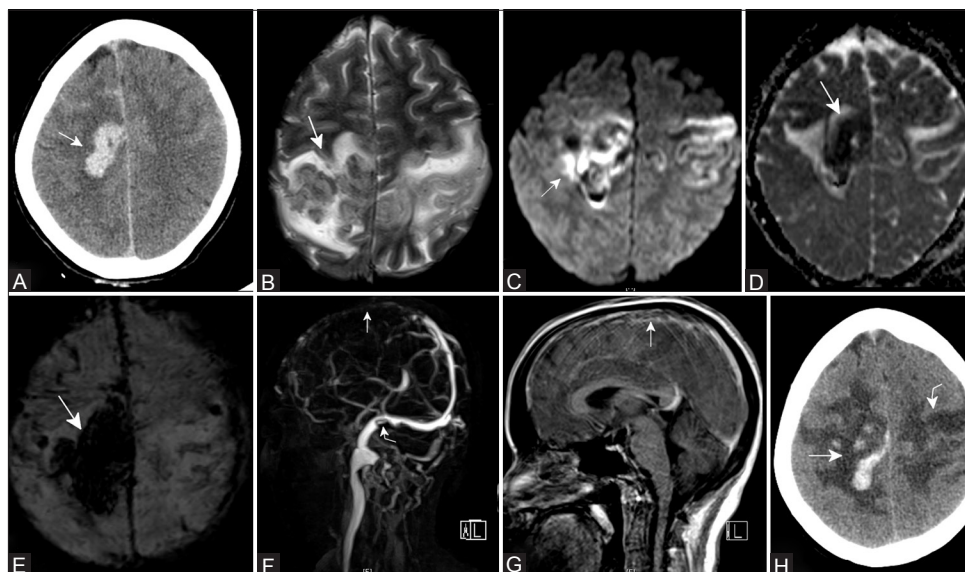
(A-H): Non-contrast CT brain axial images shows hyperdense area (arrow) in the parasagittal aspect of right high parietal region suggestive of a haemorrhagic infarct (A) MRI brain done the next day shows heterogeneous lesion (arrows) in FLAIR and T2 (B-D) with blooming on SWI (E) in right parasagittal parietal region keeping with an infarct with haemorrhagic transformation. MRV shows filling defects in the superior sagittal sinus (straight arrow), right transverse (curved arrow) and sigmoid sinuses (F and G). CT brain done 6 days later shows (H) increase in haemorrhagic component in the right high fronto-parietal region (straight arrow) and new hypodense lesion in left high fronto-parietal region (curved arrow) with small foci of haemorrhage
